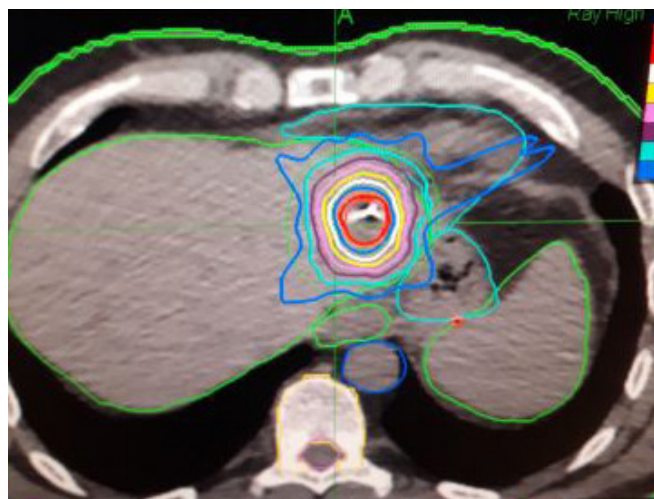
Planning CT of SBRT, axial image
